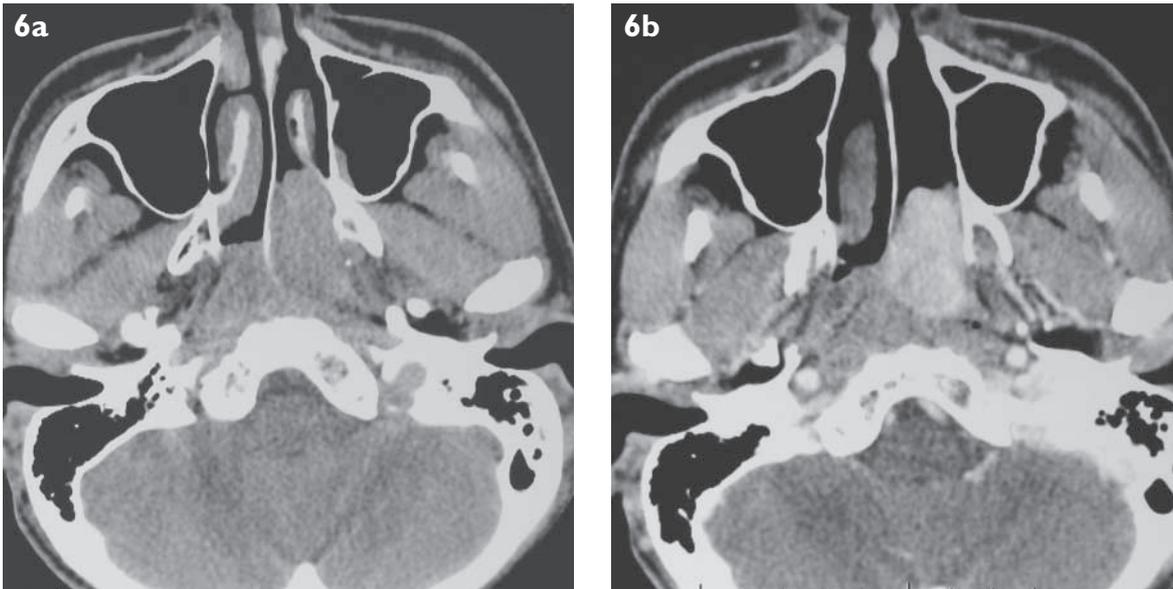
CT appearances of juvenile nasopharyngeal angiofibroma. (a) Unenhanced and (b) enhanced axial scans show a mass in the left nasopharynx, which extends into the nasal cavity, and demonstrates intense homogeneous enhancement.
